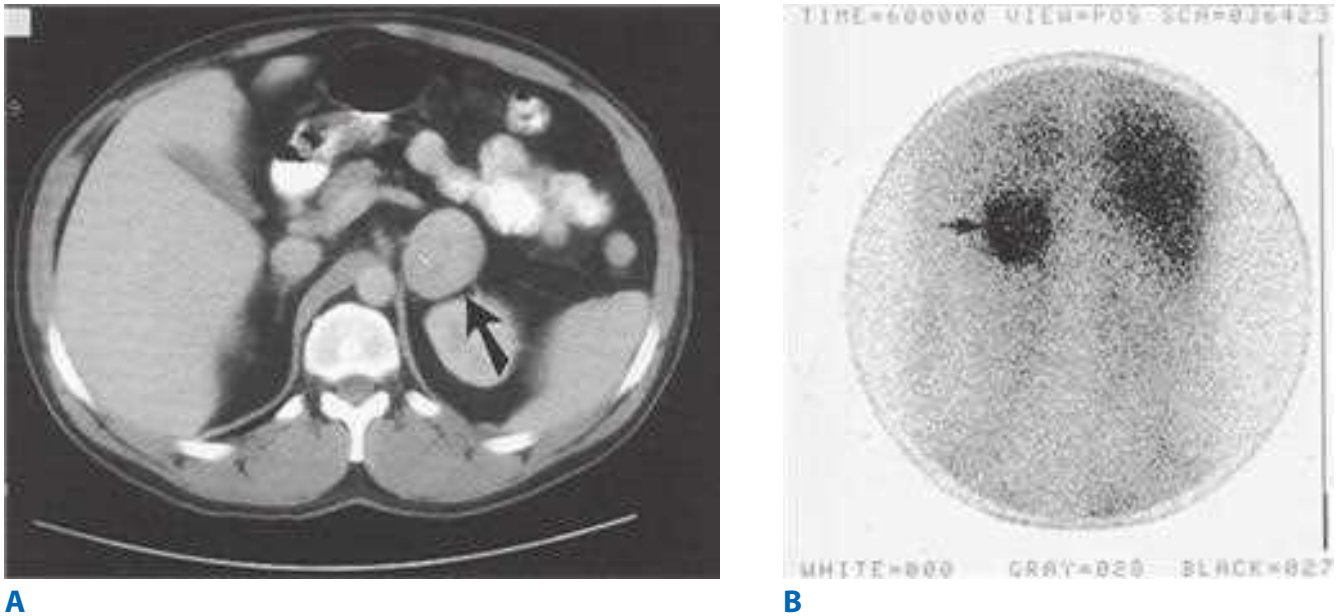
A left-sided pheochromocytoma (arrows) imaged by a computed tomography scan of the abdomen (A) and a metaiodobenzylguanidine scan viewed posteriorly (B).
